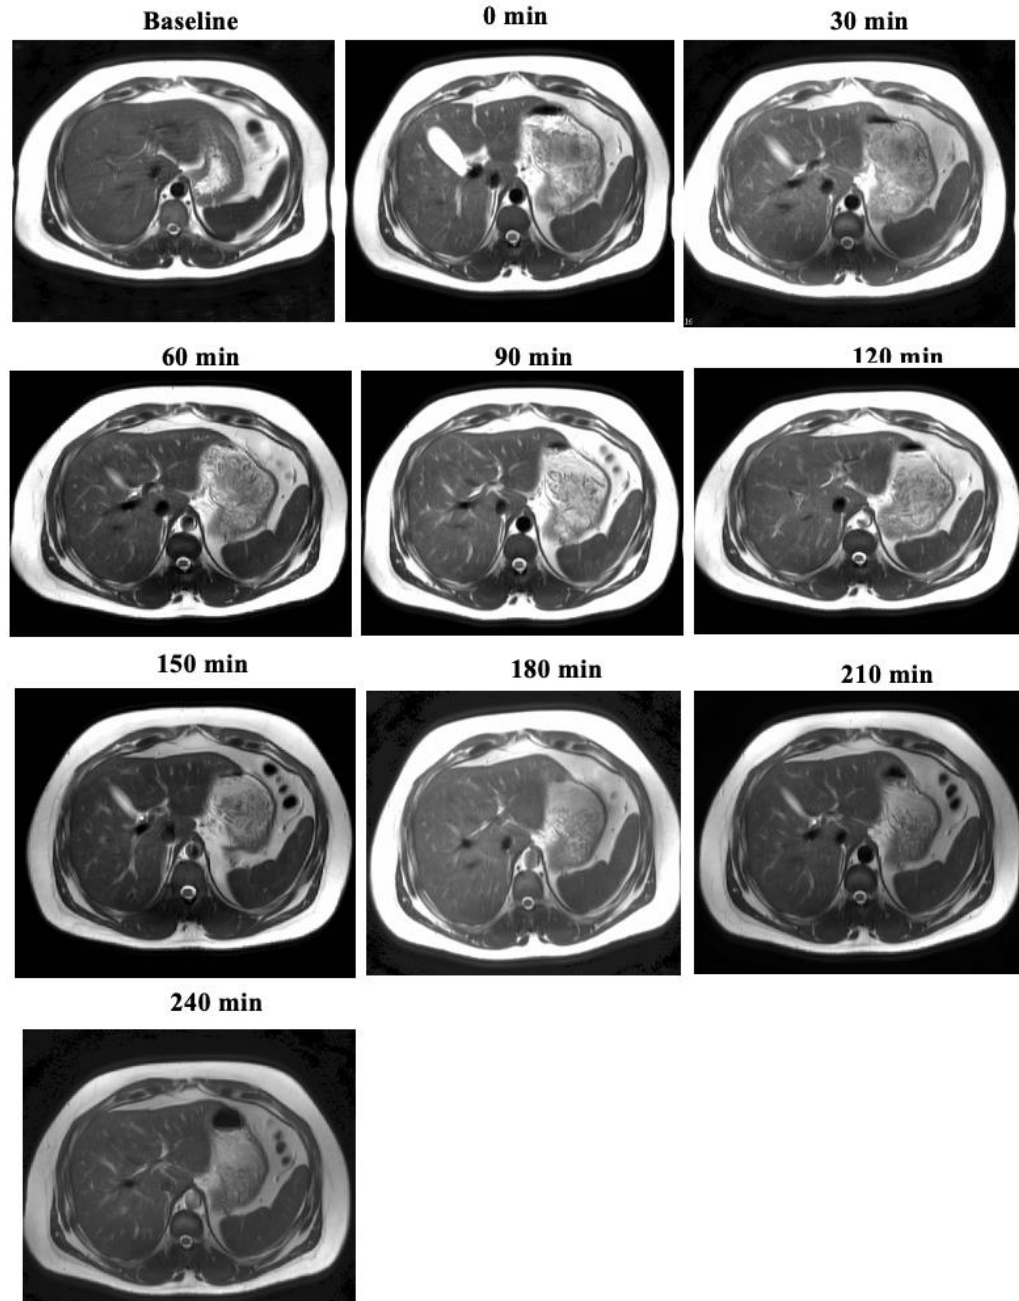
MRI images of stomach of a participant with obesity at fasting baseline and after consumption of the test meal.
